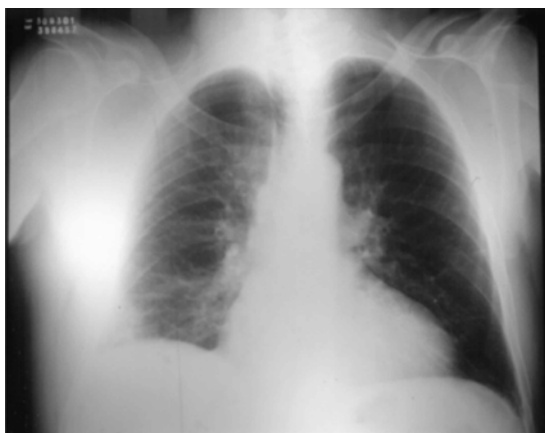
Chest X-Ray of patient 3 after 5 weeks shows almost complete regression of pulmonary lesions.
